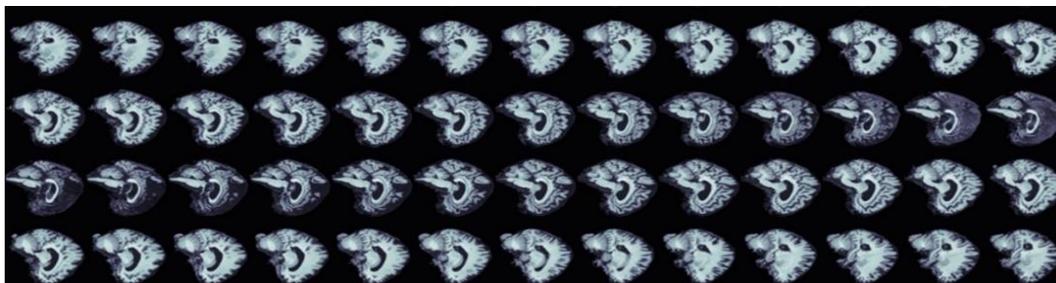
Pre-processed Medial Sagittal Planes of Brain MRI.
